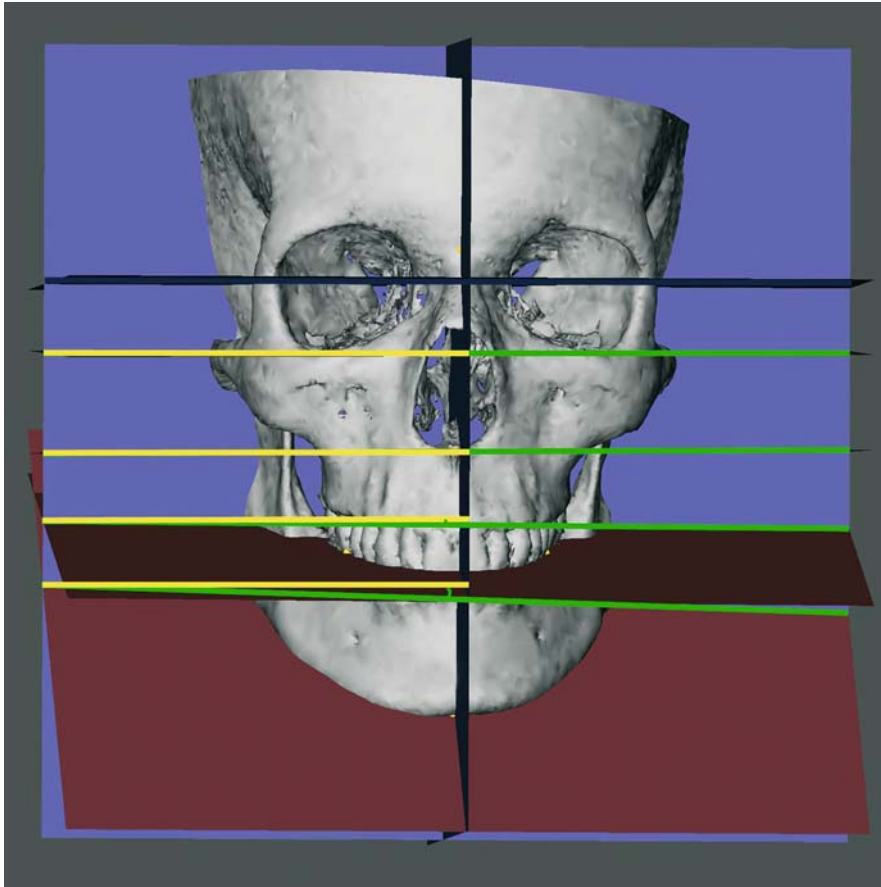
The frontal inclinations of the Frankfort horizontal plane (FH-PI), the maxillary plane (Mx-PI), the occlusal plane (Occ-PI) and the mandibular plane (Md-PI) from the horizontal (x) 3-D cephalometric reference plane are projected angular measurements on the vertical (y) 3-D cephalometric reference plane (3-D CT, hard tissues, patient K.C.)
